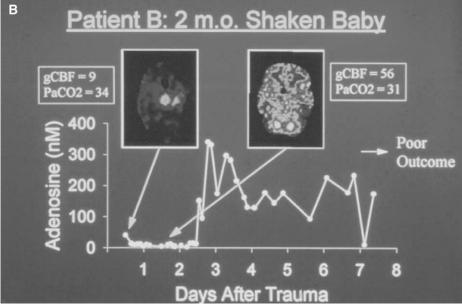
(A) CBF in a 15-year-old child in a motor vehicle accident (MVA) measured by stable xenon CT. Normal global CBF (gCBF) concurrent with increased cerebrospinal fluid (CSF) adenosine levels was observed. This may reflect an appropriate cerebrovascular response to adenosine release early after injury. (B) CBF in a 2-month-old child with shaken baby syndrome measure by stable xenon CT. Marked early hypoperfusion with a low gCBF was noted concurrent with surprisingly low CSF adenosine levels. Subsequent increases in both gCBF and CSF adenosine levels were seen. This pattern may reflect overwhelming injury with an initial failure of the endogenous adenosine response. The late rise may reflect pathologic vasodilation, CBF dysregulation, or marked CBF demands coupled to increased anaerobic metabolism. (See also Color Plate 1.)
